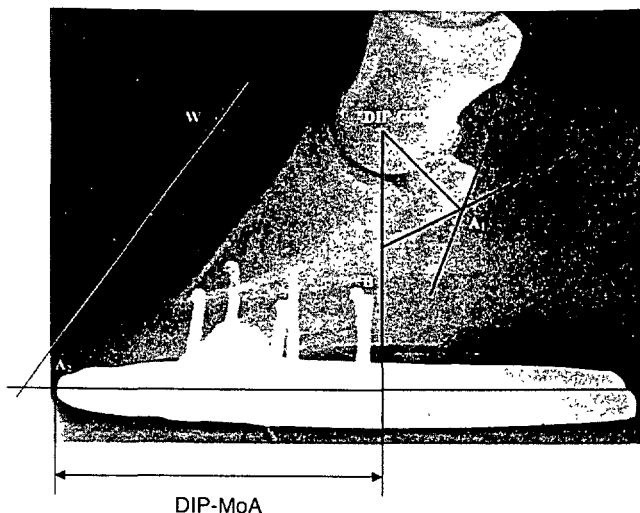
Lateromedial radiograph of a foot with a quarter-clip shoe. DIP-CoR = distal interphalangeal joint centre of rotation; DIP-MoA = DIP joint moment arm measured from the toe region of the shoe to the vertical line (B) drawn from DIP-CoR; C = distance from DIP-CoR to the flexor surface of the navicular bone (DDFT moment arm); A_1 = angle of deviation of the deep digital flexor tendon around the navicular bone; A_2 = dorsal hoof wall angle.
